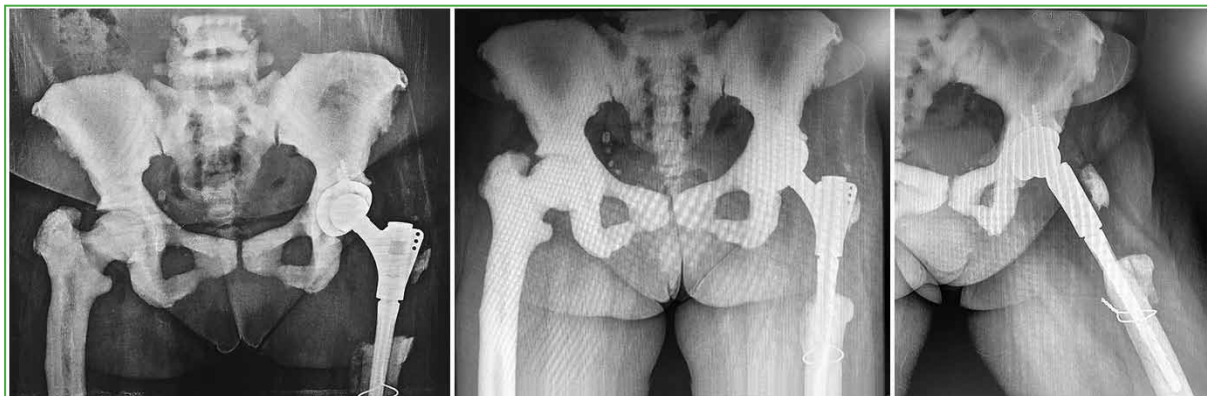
From left to right: Postoperative control radiograph a year later, without dislocations, loosening or osteolysis. Postoperative control radiograph at 3 years, without loosening or osteolysis of the prosthesis.
